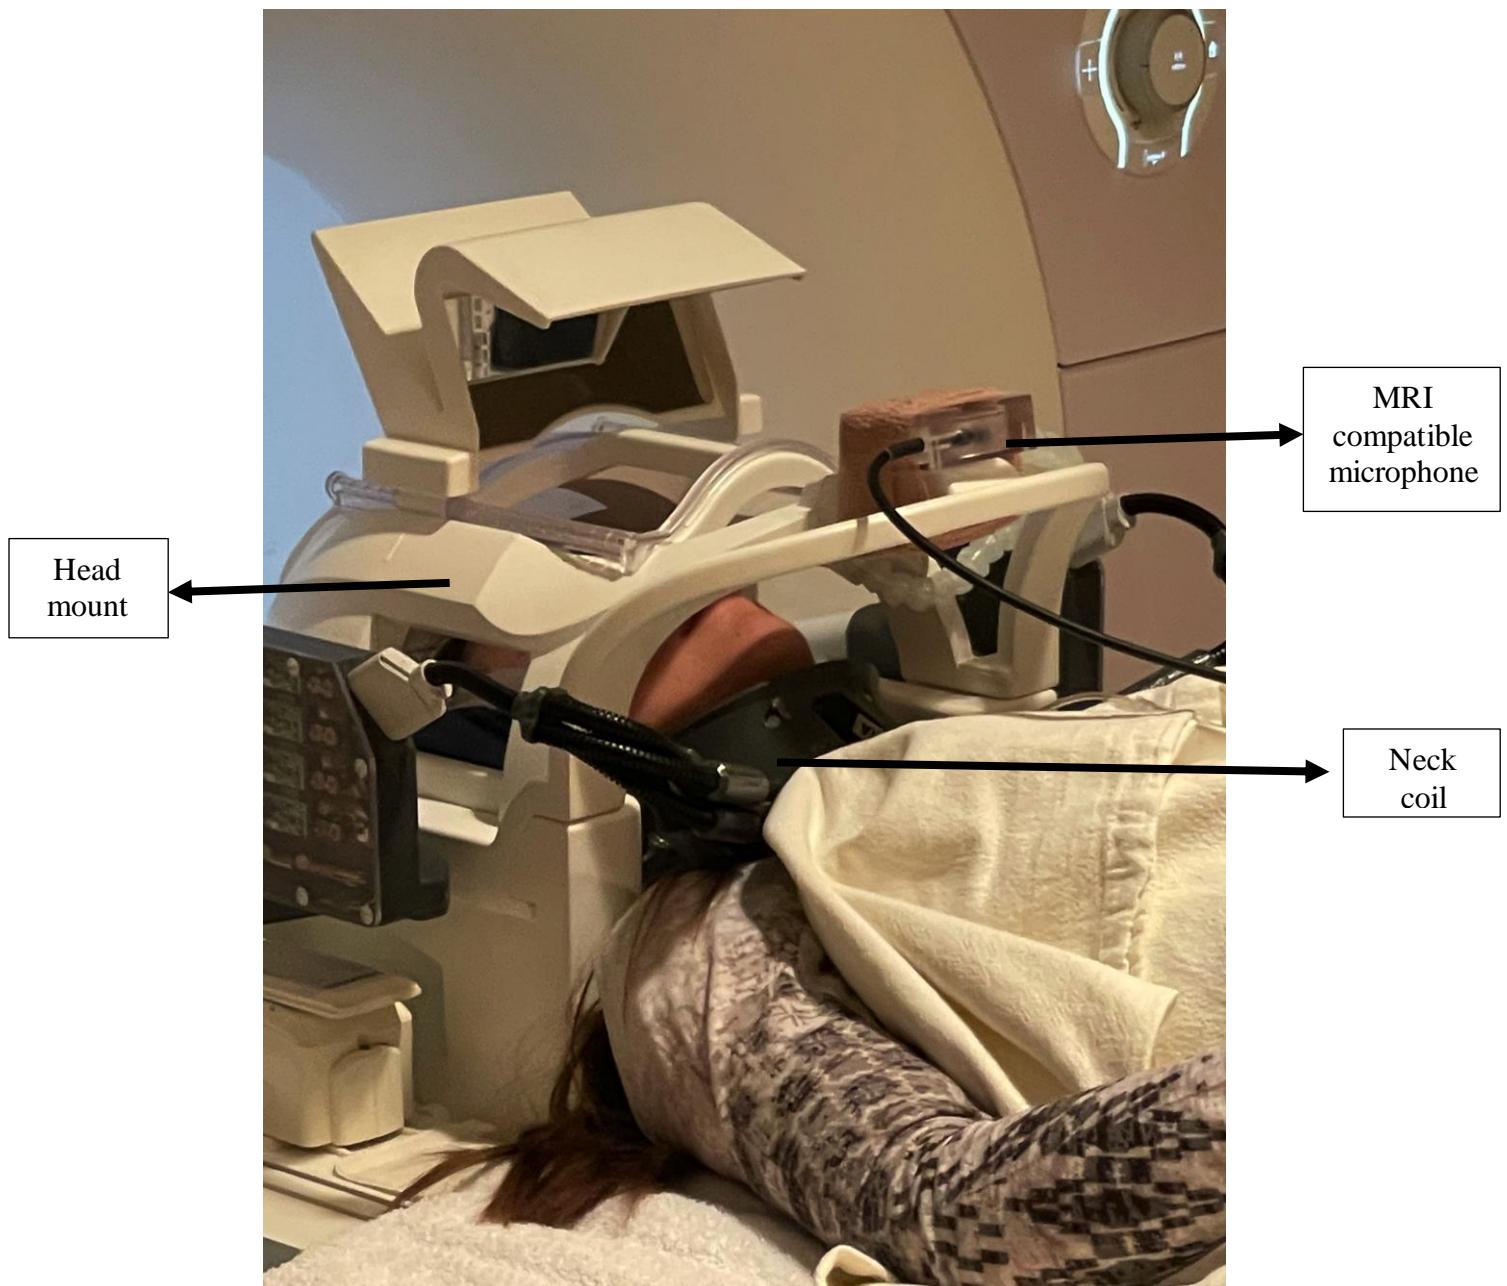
MRI scanner session 2 with participant fitted with head mount, MRI microphone and 7-channel neck coil.
